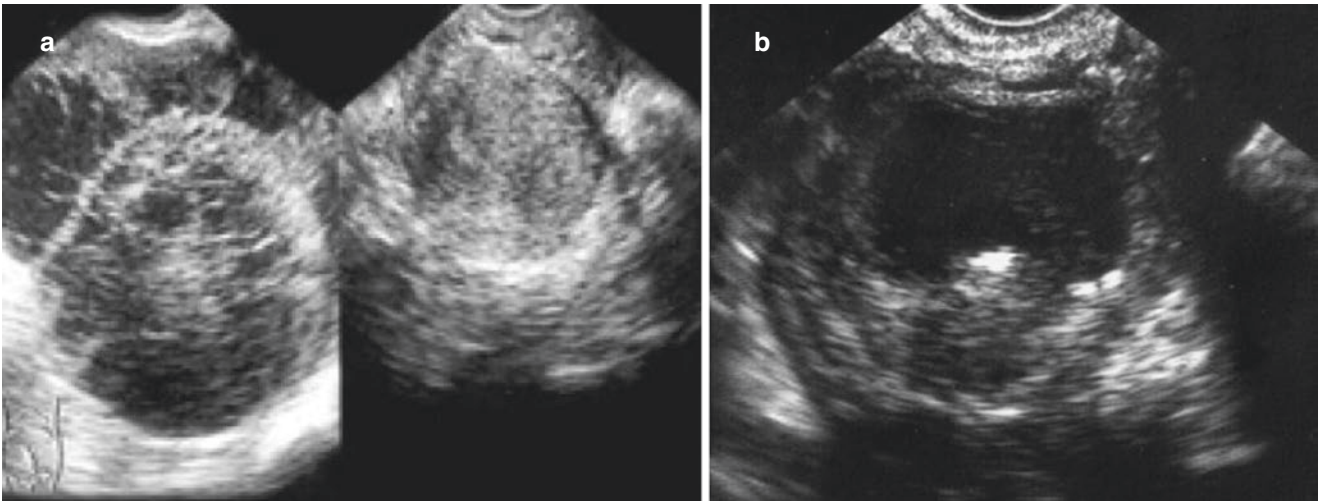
Postpartum pelvic inflammatory mass. (a). 11 days after labor induction, the patient has a fever and abdominal pain. Ultrasonography examination shows the heterogeneous, irregular masses on the right side of the pelvic cavity without a conspicuous
